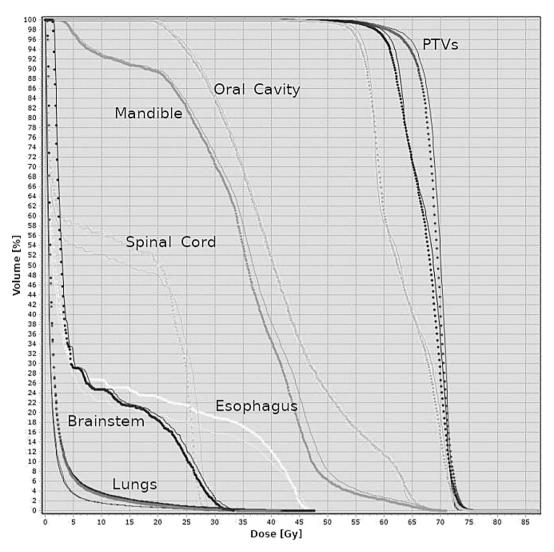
DVHs calculated by TPS (solid) and DI (dashed) system on the patient CT-dataset for a head and neck treatment site.
